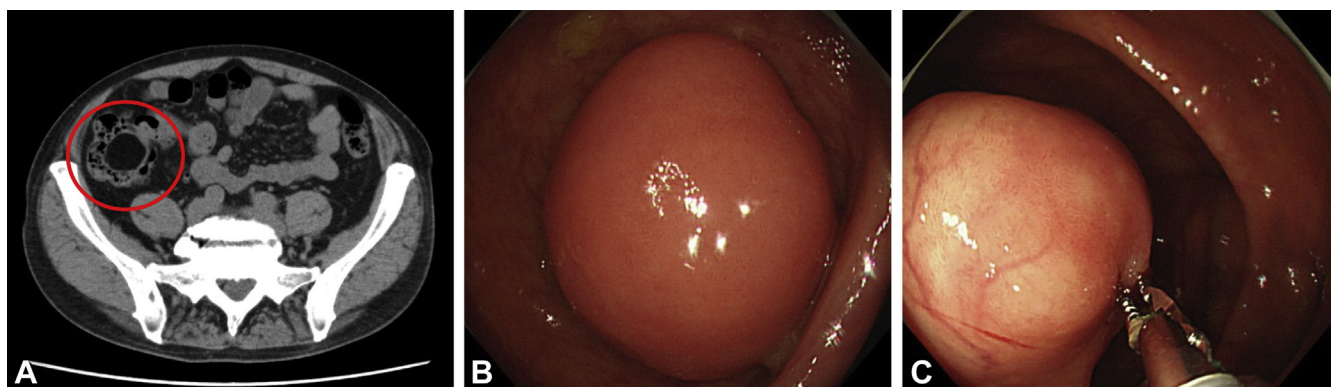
A, CT scan showing a mass located in the terminal ileum. B, Submucosal tumor measuring 40 mm in diameter located in the terminal ileum. C, The tumor was soft and could be easily pulled into the cecum through the ileocecal valve.
